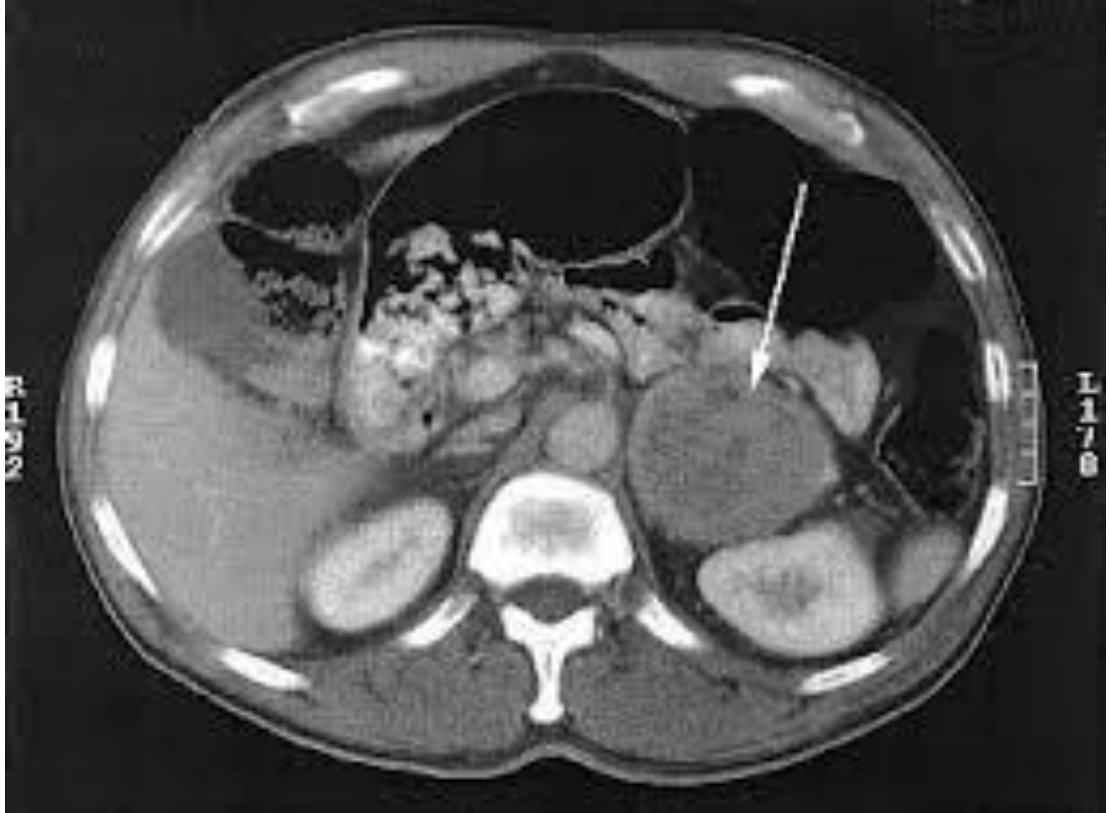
CT pheochromocytoma on the right.
